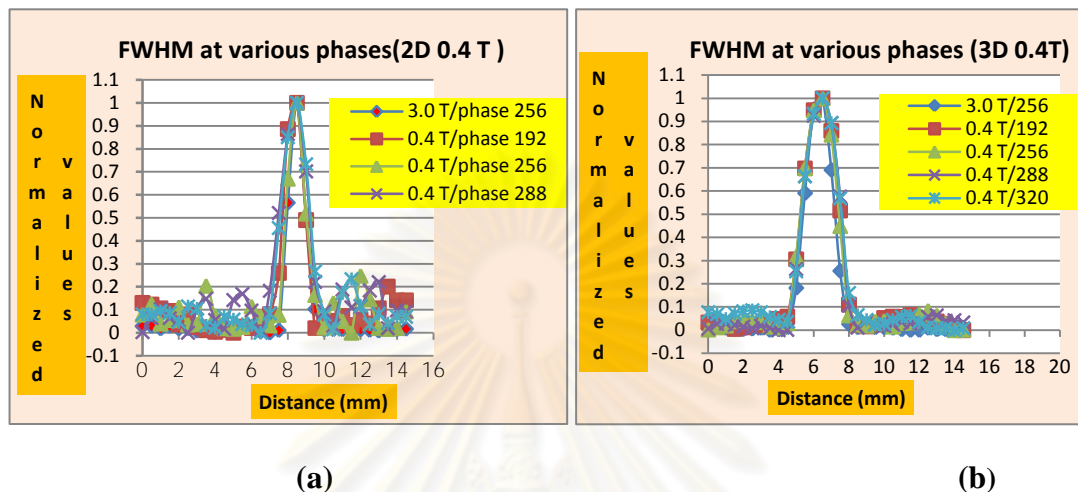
FWHM versus phase of 2D (a) and 3D (b) images at MRI 0.4 T compared to number of phase 256 at MRI 3.0 T
